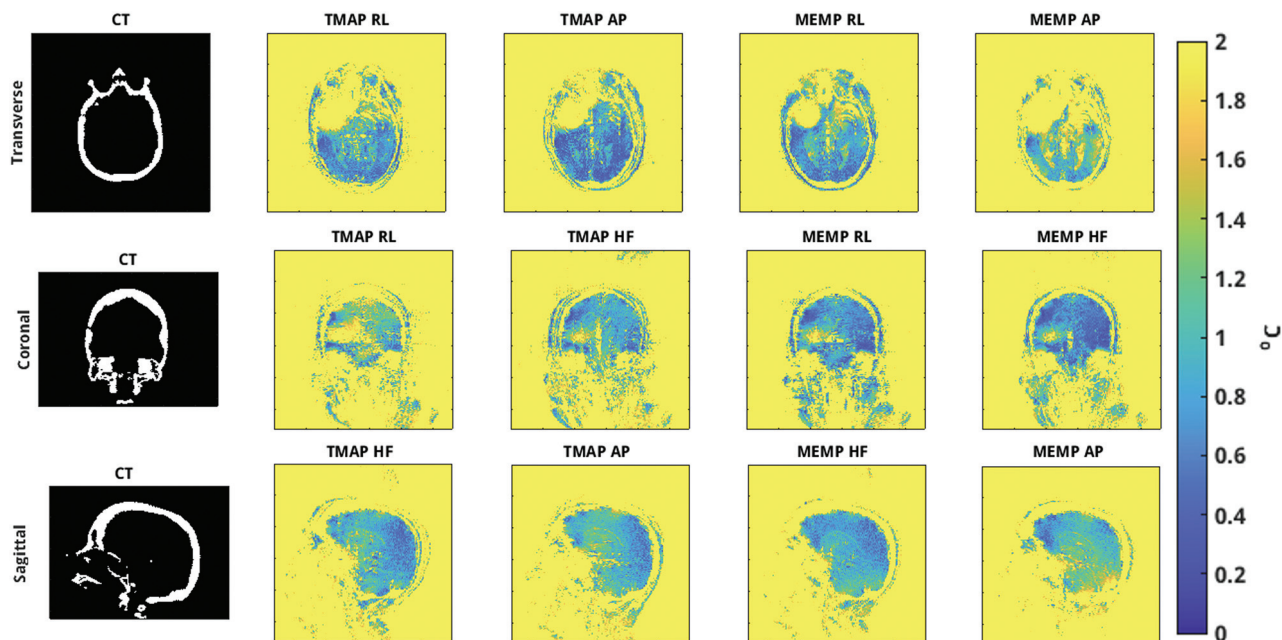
CT scan and precision of MRT scans. MRT precision is measured as the standard deviation through time. For all 3 orientations, both phase-encoding directions for both the single-echo and multi-echo MRT sequences are shown. The scans were performed in the Exablate transducer (without the coupling water bath) with a 2-channel radiofrequency receiver coil. The patient's head was stabilized with pads, but no stereotactic frame was used. The scans were performed before the patient's head was shaved.
